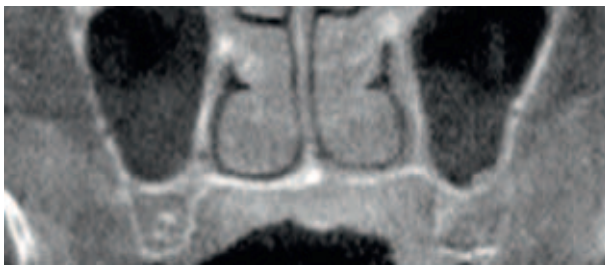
A Cone Beam CT scanning revealed a lesion in left side of hard palate with focal bony destruction. A) Coronal plane. B) Sagittal plane
